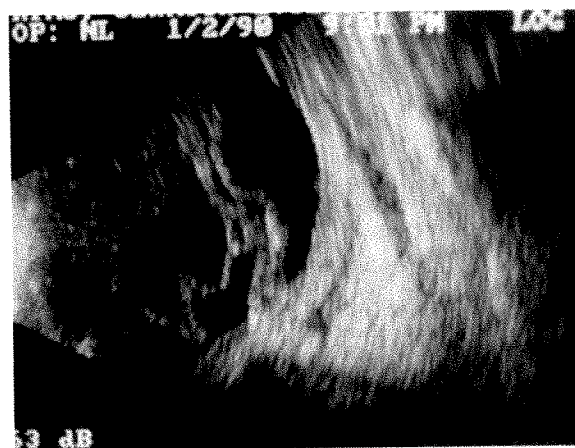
(Havunjian, Goldberg, and Hepler). Orbital ultrasound showing dense vitreous opacification with membrane formation, posterior scleritis, and diffuse orbital widening with infiltrates.
